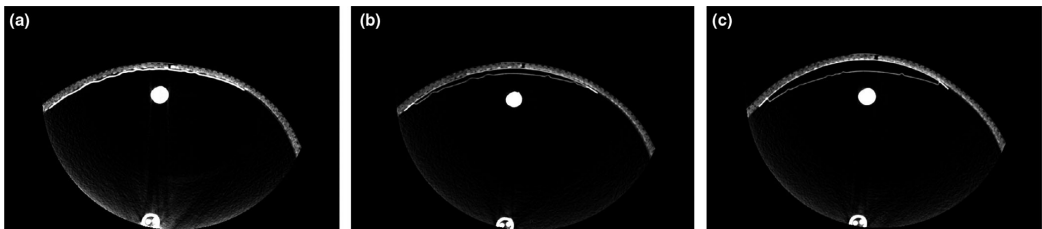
Cone-beam computed tomography images of target 4 showing (a) no abdomen enlargement, (b) small abdomen enlargement, and (c) medium abdomen enlargement.
